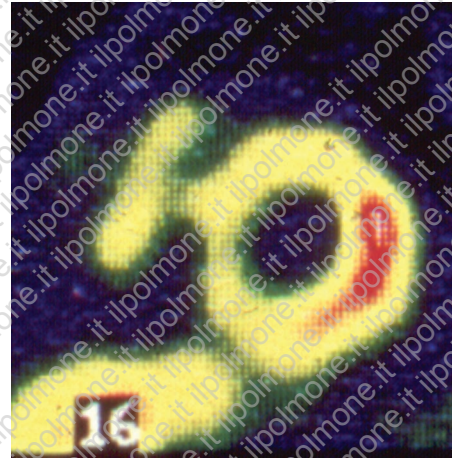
Cardiac sarcoidosis in a 60-year-old man who presented with complete atrioventricular blockage. Image obtained with Ga-67 citrate single photon emission computed tomography (short-axis view) shows diffuse abnormal radiotracer accumulation in the myocardium. Areas of strong uptake represent foci of increased disease activity.
